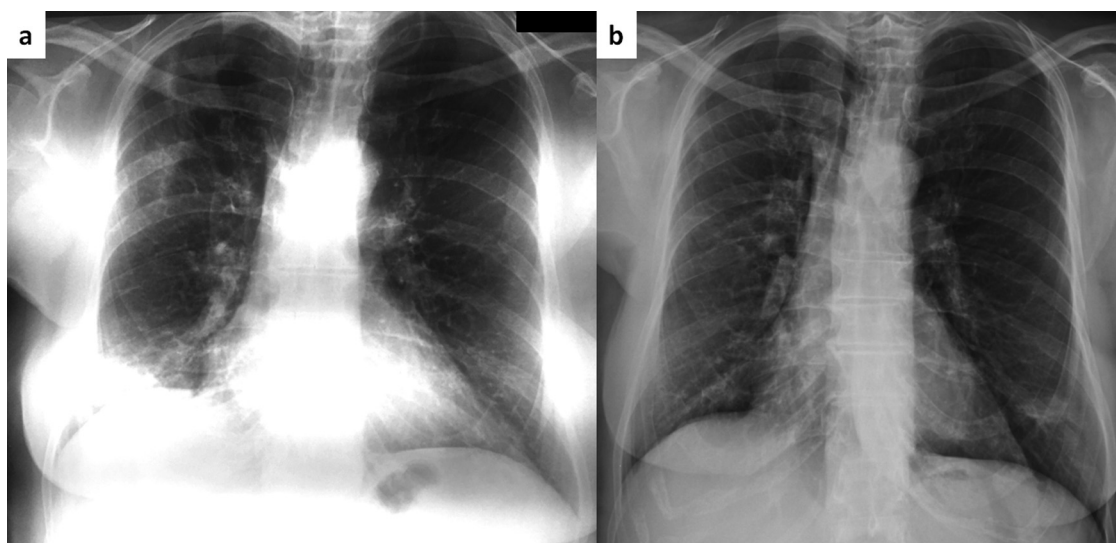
Same patient as Figure 1. Chest roentgenogram 5 months after cessation of steroids with areas of consolidation in the right upper and lower lung zone (panel a). After two months of treatment with azithromycin (250 mg thrice weekly), there is a complete resolution of abnormal findings (panel b).
